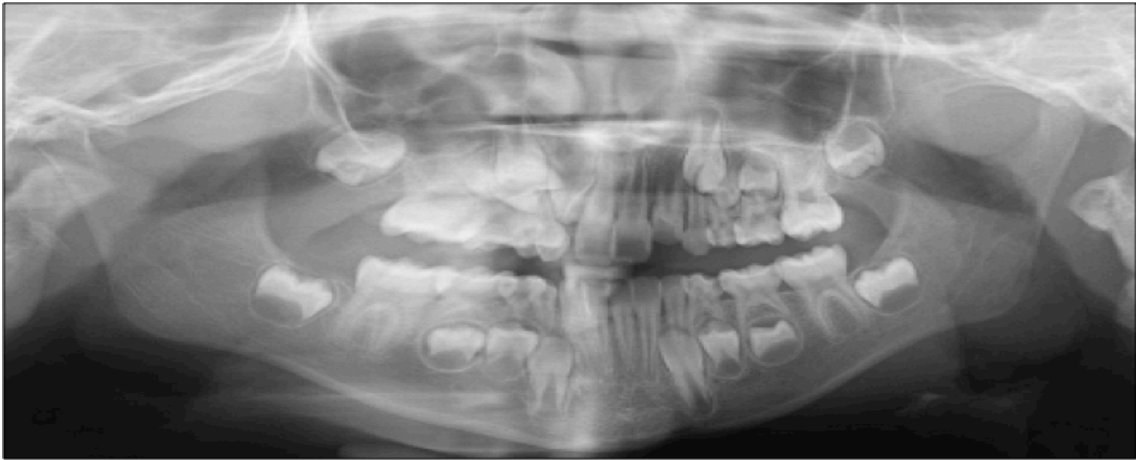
Panoramic radiography of the patient taken before dental treatment.
